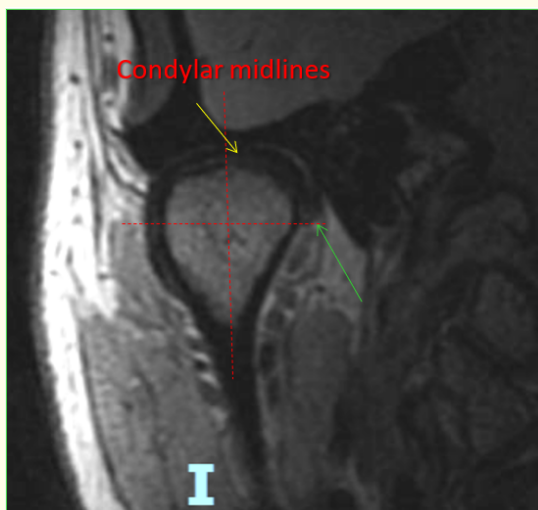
MRI of the right TMJ on coronal view. This image only confirms the findings on figure 10. *Yellow arrow:* superior limit of the articular disc on the right TMJ, severely/totally in medial displacement, crossing the vertical midline at twelve-hour mark. *Green arrow:* inferior limit of the articular disc, severely medially displaced, reaching the horizontal midline at three-hour mark.
